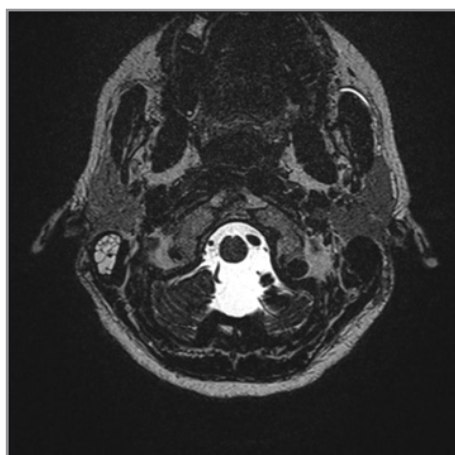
(MRI scan: stationary)
